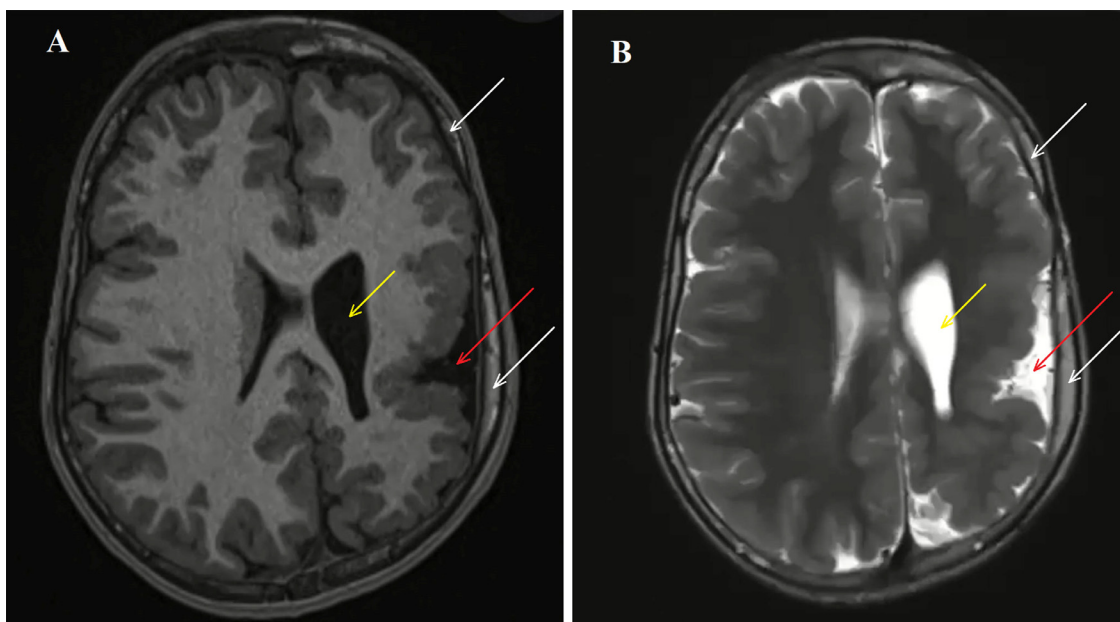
Axial MRI images: (A) T1-weighted image and (B) T2-weighted image; demonstrating left cerebral hemiatrophy (red arrows), with left ventricular dilatation (yellow arrows), and calvarial thickening on the affected side (white arrows).
